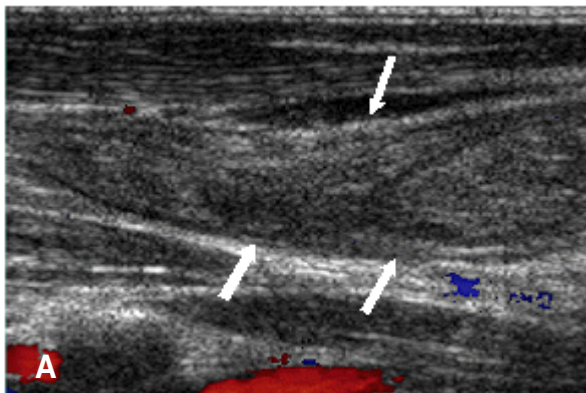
Initial color Doppler ultrasonogram (A) shows obstruction of the right internal jugular vein (white arrow). Two months later color Doppler ultrasonogram (B) demonstrates a completely resolved thrombosis within the right internal jugular vein (black arrow).
